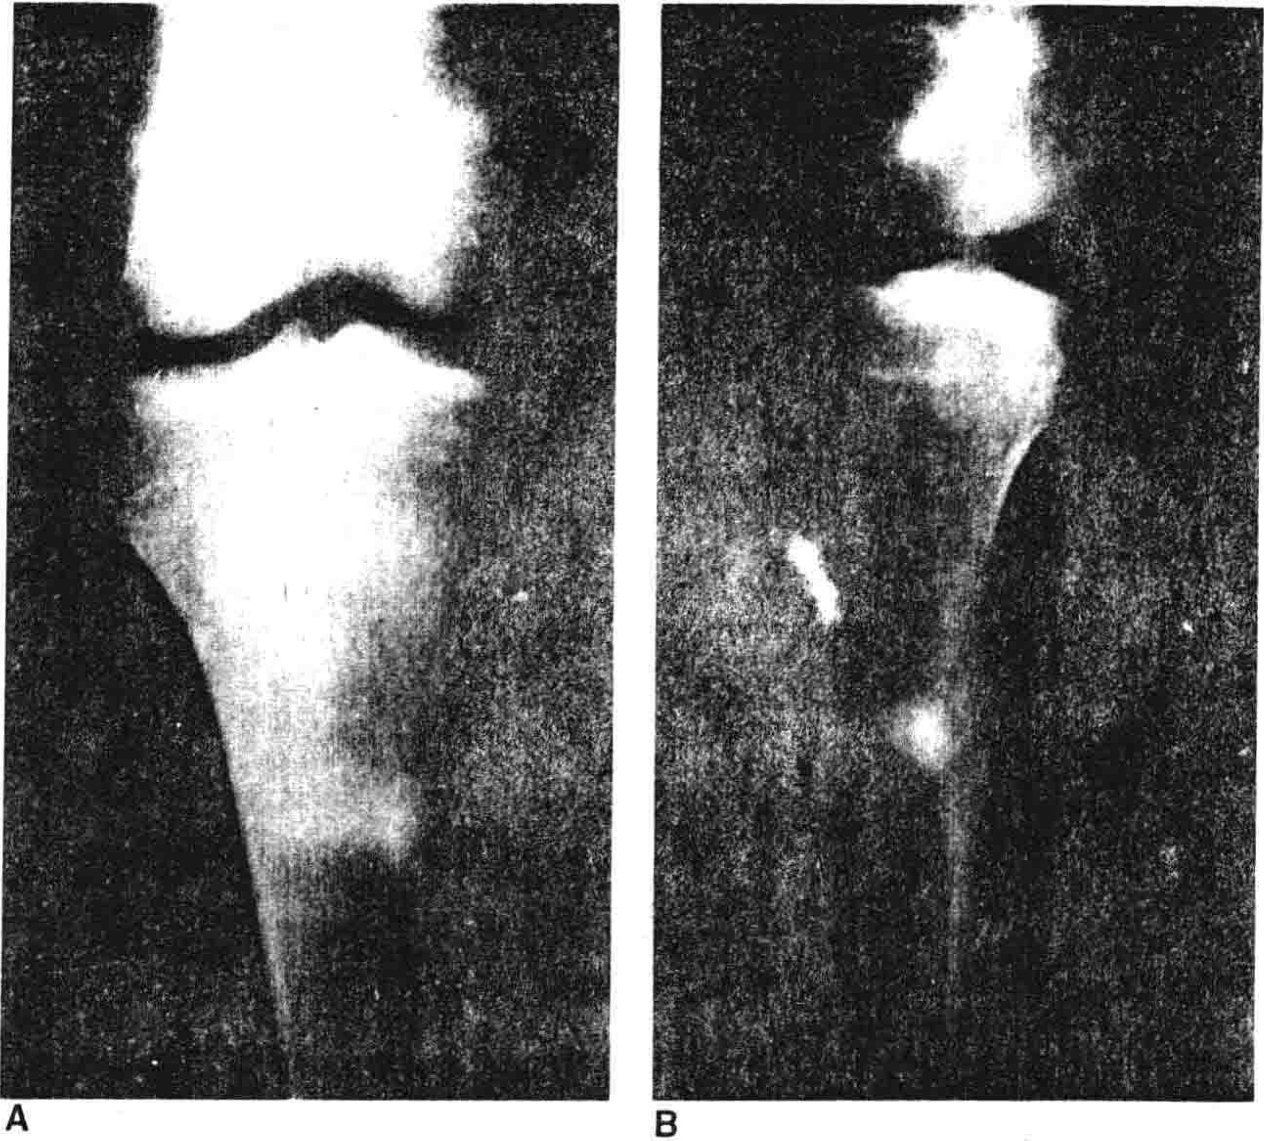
(A) anterior-posterior and (B) lateral radiographs of stress fracture in a long-distance runner. The proximal tibia is more common in children.
